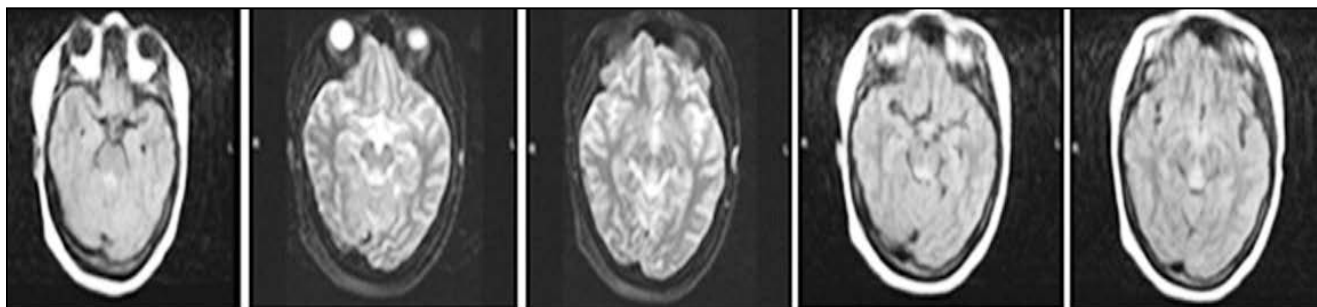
Bilateral symmetric hyperintensity alterations on T2-weighted, and FLAIR MR images in the periphery of the third ventricle, periaqueductal area, and mammillary bodies.
